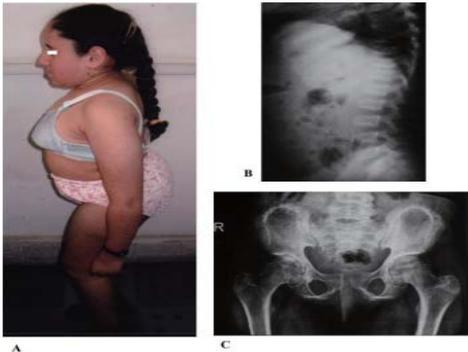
Case 10 with SMC dysplasia at 13 years and 6 months of age. Lateral view showing the clinical features (A). X-ray (Lateral view) of lumbar vertebrae showing platyspondyly with central constriction of vertebral bodies (B). X-ray of pelvis showing the characteristic lace like appearance of iliac bones and the decreased bone density (C).
